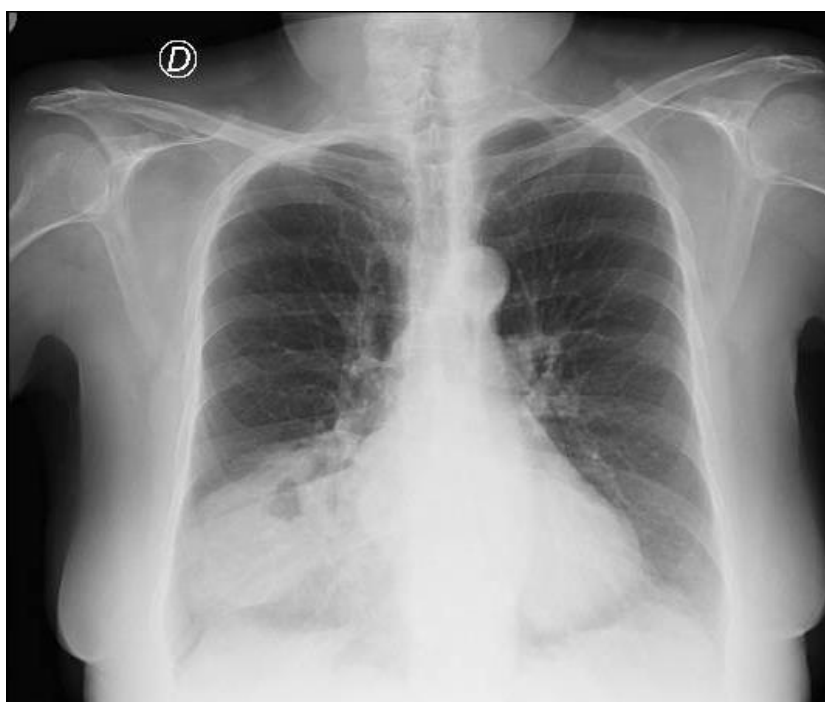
Chest X-ray showing widening of the mediastinum and a few air-fluid levels.
